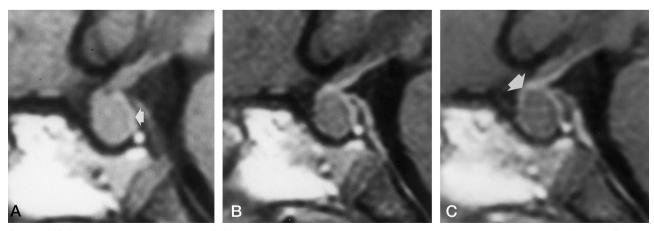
MR findings in a 23-year-old man (D.M.) with severe growth failure caused by combined pituitary hormone deficiency. Sagittal T1-weighted (550/20/2) noncontrast image (A) shows minimally enlarged pituitary gland, with a thin posterior bright spot of the neurohypophysis (*arrow*). Immediate (B) and delayed (C) postcontrast images fail to reveal enhancement within the gland. Only a peripheral rim of enhancement is present (*arrow*, C), which we believe is related to an abnormal vascular supply or to replacement of the pituitary gland by a nonenhancing mass.
